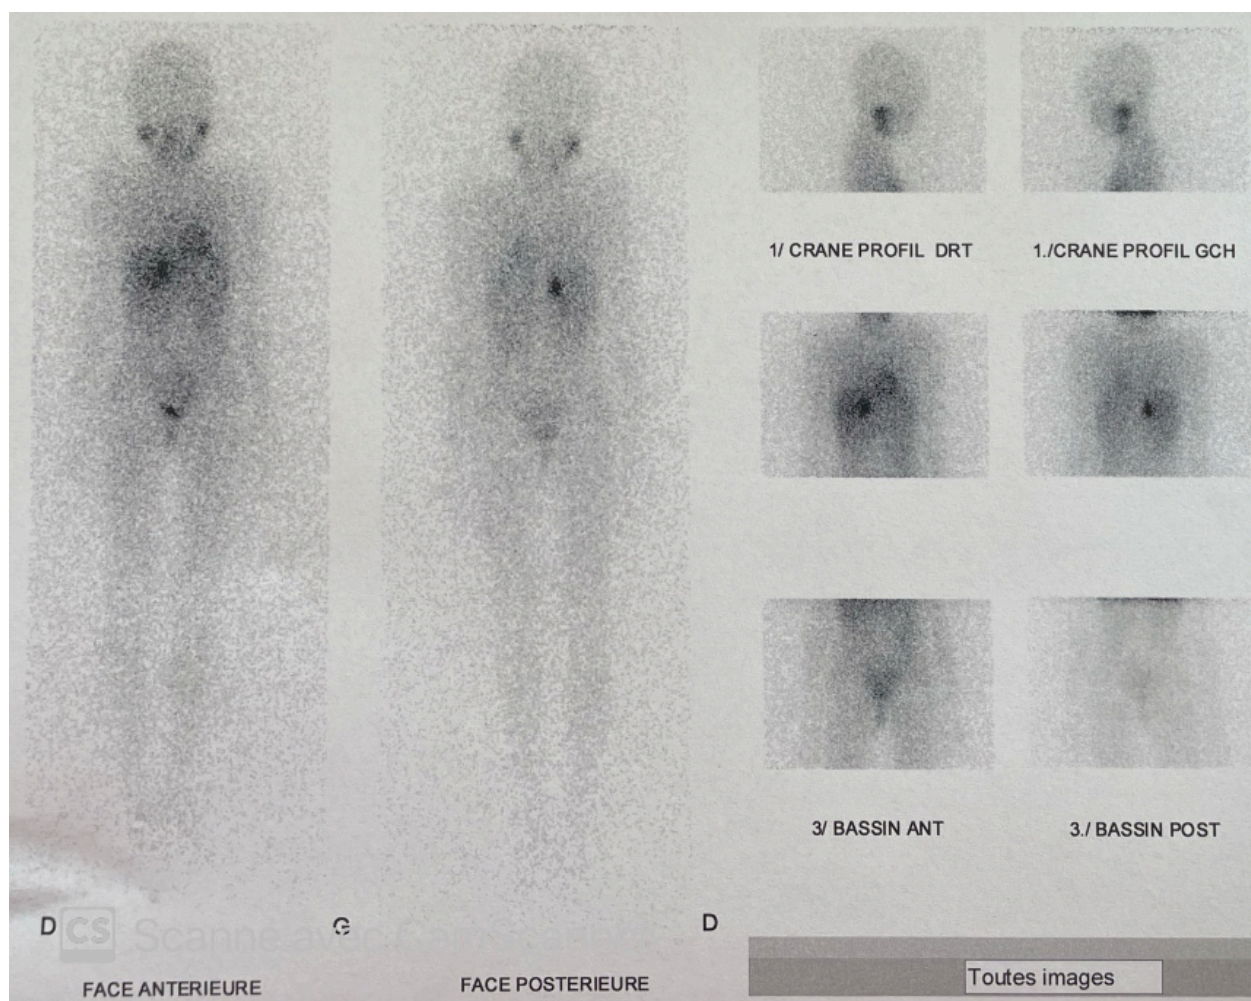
Whole-body static MIBG scintigraphy images showing intense uptake in the right suprarenal primary tumor (indicated by the green arrow) and metastatic bone lesions (indicated by the red arrows).
